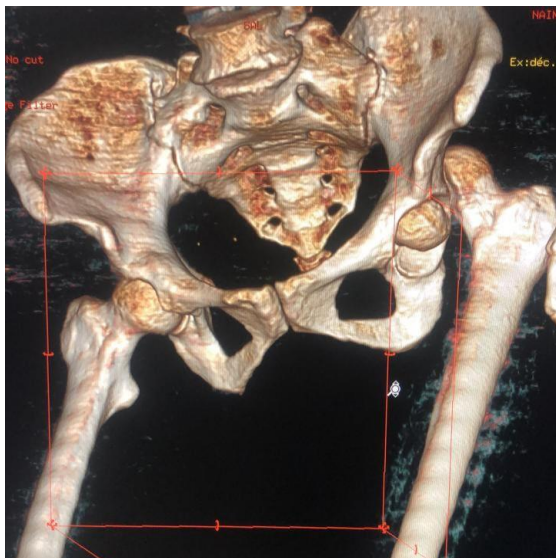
Anterior front view of the 3D CT scan of the pelvis confirming the fracture dislocation of the left femoral head
